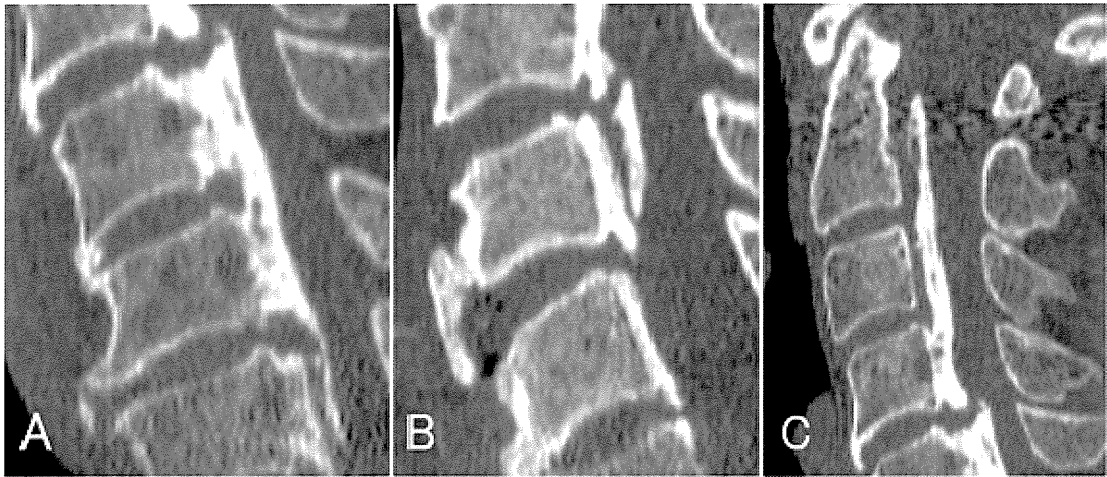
Computed tomography scans showing the bridging (A), nonbridging (B), and stalagmite (C) types of ossification.
